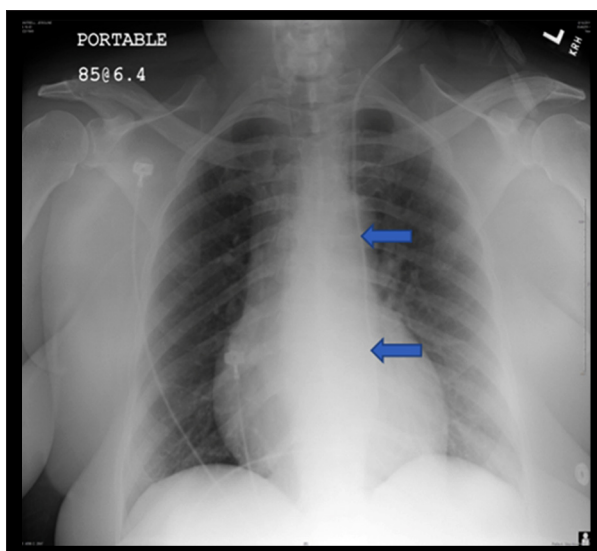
Chest X-ray showing the course of the central venous catheter (arrows) from the left internal jugular insertion site. The catheter remains on the left of the spine in the vein of Marshall instead of going to the right in the superior vena cava.
